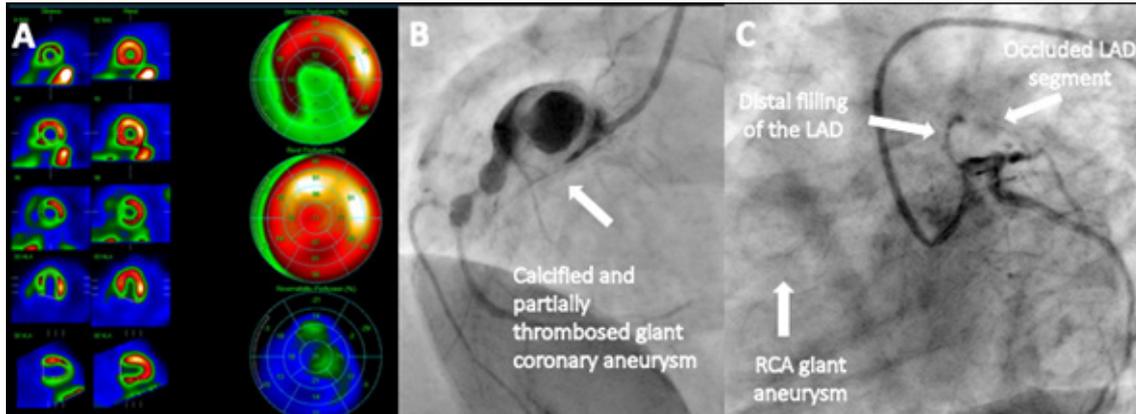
A) SPECT showing 45% area of LV ischemia; B) RCA; C) Left coronary artery.
